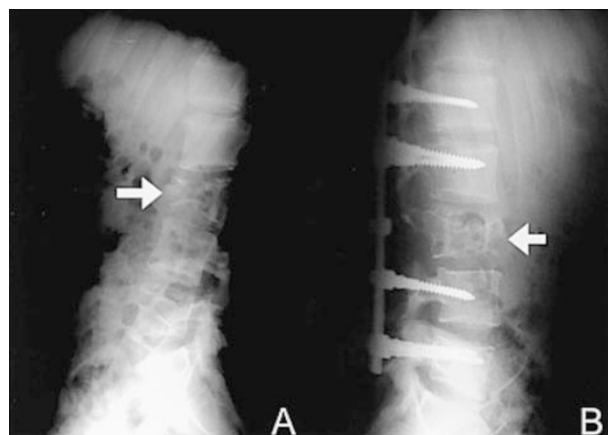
(A,B) Preoperative and postoperative lateral radiographs show anterior wedging of the third lumbar vertebral body with moth-eaten appearance (arrows)
